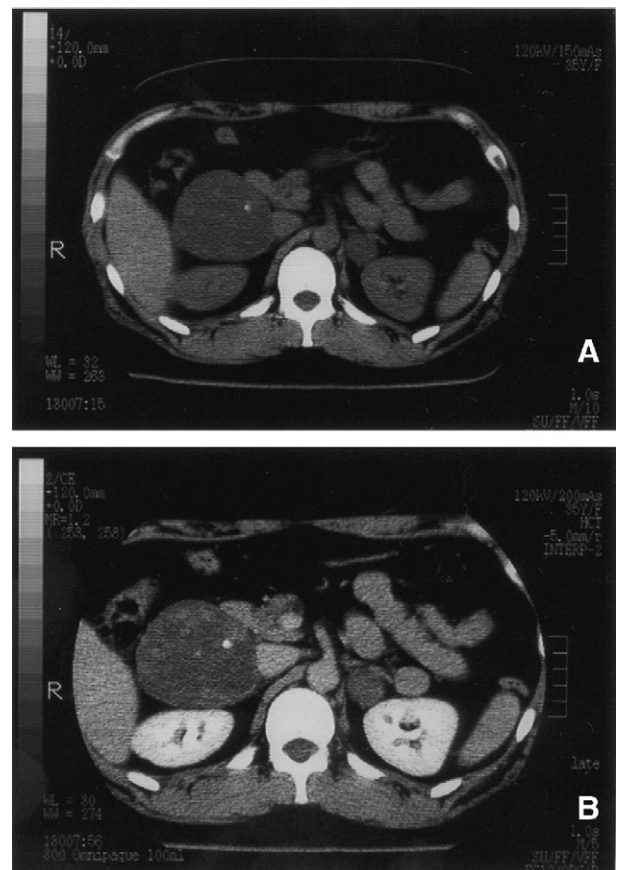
CT scan image of the abdomen demonstrating a well-circumscribed low-density mass with calcification, approximately 7 cm in size, located in the region of the right adrenal gland. Also shown is a 2-cm low-density mass located near the superior portion of the left kidney. (A) Precontrast image; (B) postcontrast image.
